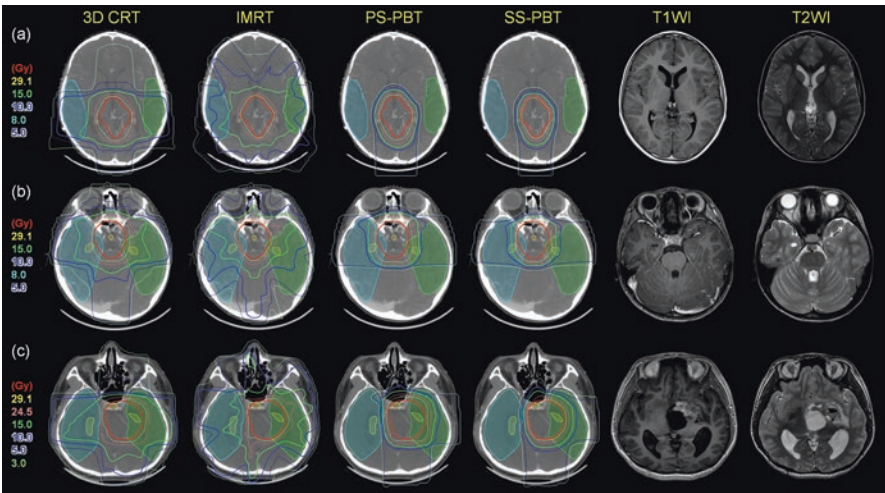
Dose distributions of primary site boost irradiation to pineal gland, suprasellar, and basal ganglia tumors with their pre-chemotherapy MRI images. *Thick red lines* are primary site PTV. *Thick blue lines* represent 10 Gy, and *green lines* represent 15 Gy isodose line. Prescribed dose is 30.6 Gy at 95% volume of PTV. Tumors arising in the (a) pineal gland (b) suprasellar area (c) left basal ganglia (Calaminus et al. 2012)
